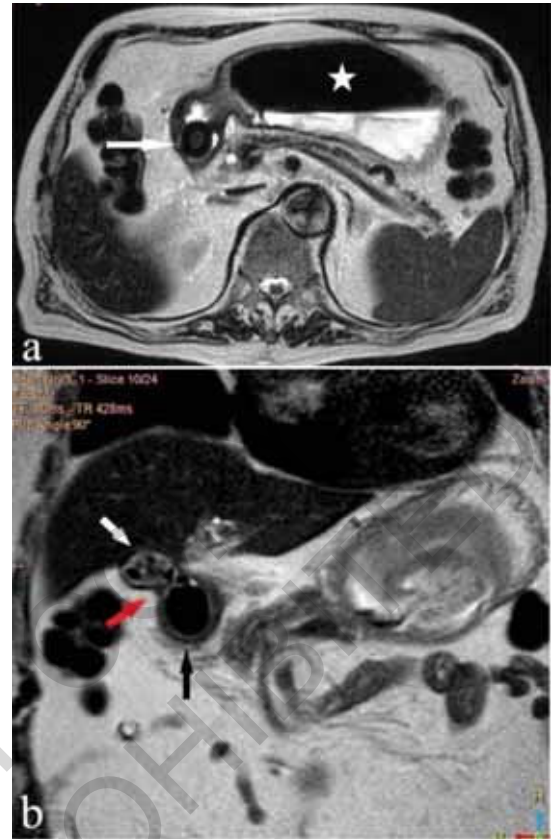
A) Axial T2 MRI: Gall Stone, hypointense at periphery and hyperintense centrally (white arrow), causing gastric outlet obstruction at duodenal bulb (white asterisk); B) Coronal T2 MRI: cholecystoduodenal fistula tract (red arrow), signal void appearance gall stone at duodenal bulb (black arrow) and gall bladder (white arrow).
